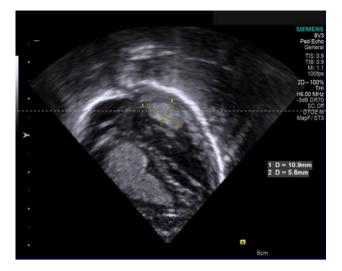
Postnatal echocardiography of the neonate in Fig. 3 at 3 weeks of age—the rhabdomyoma in the *left ventricle* has completely regressed and that in the *right ventricle* has shrunk to 11×6 mm
